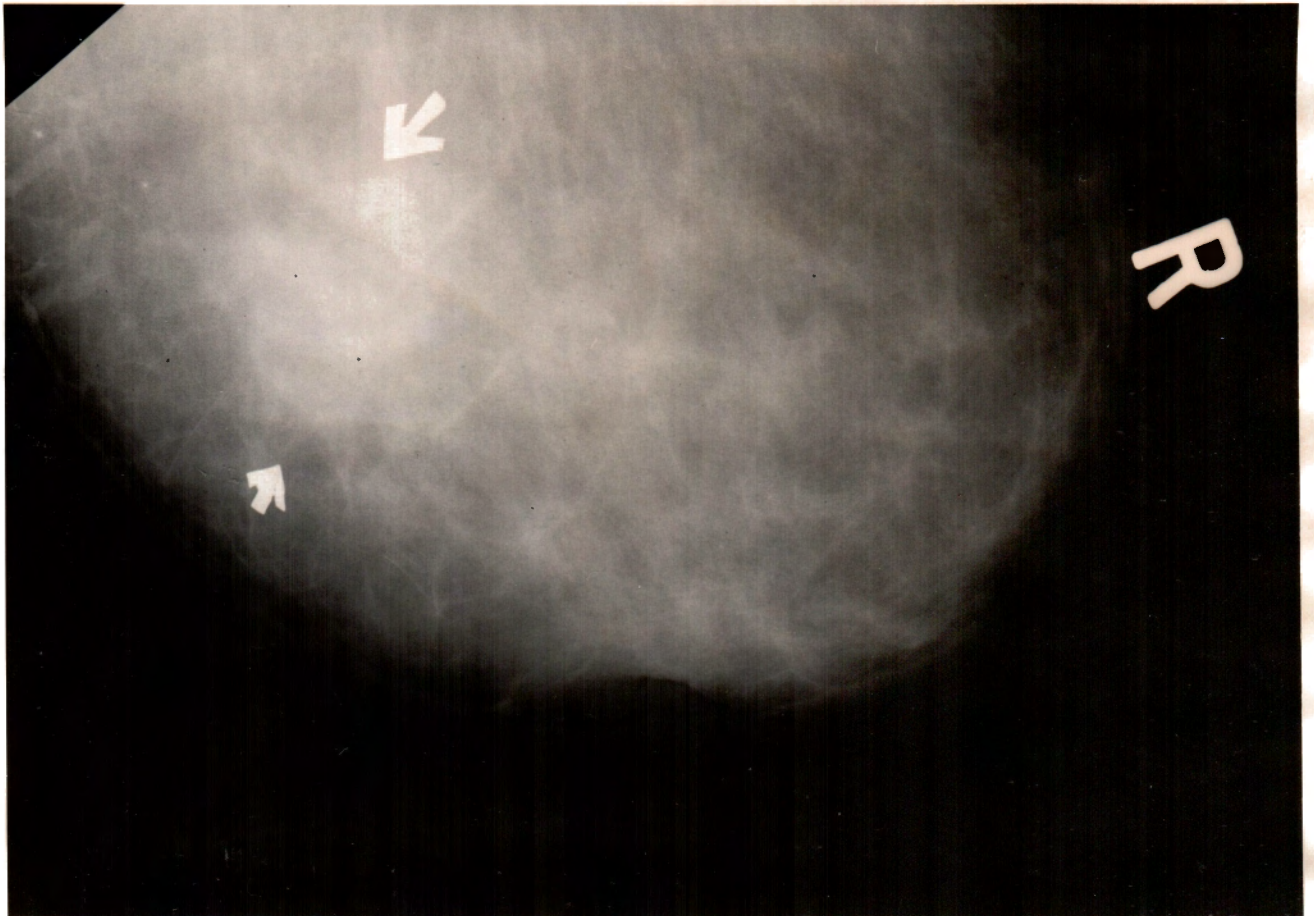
Adenocarcinoma of the breast, female, age 70. (Cranio-caudal view) The carcinoma is visualized as a large poorly defined area of increased density in the lateral aspect of the breast. The skin thickening which was clearly demonstrated on the original x-ray films is not clearly demonstrated on the photograph.
